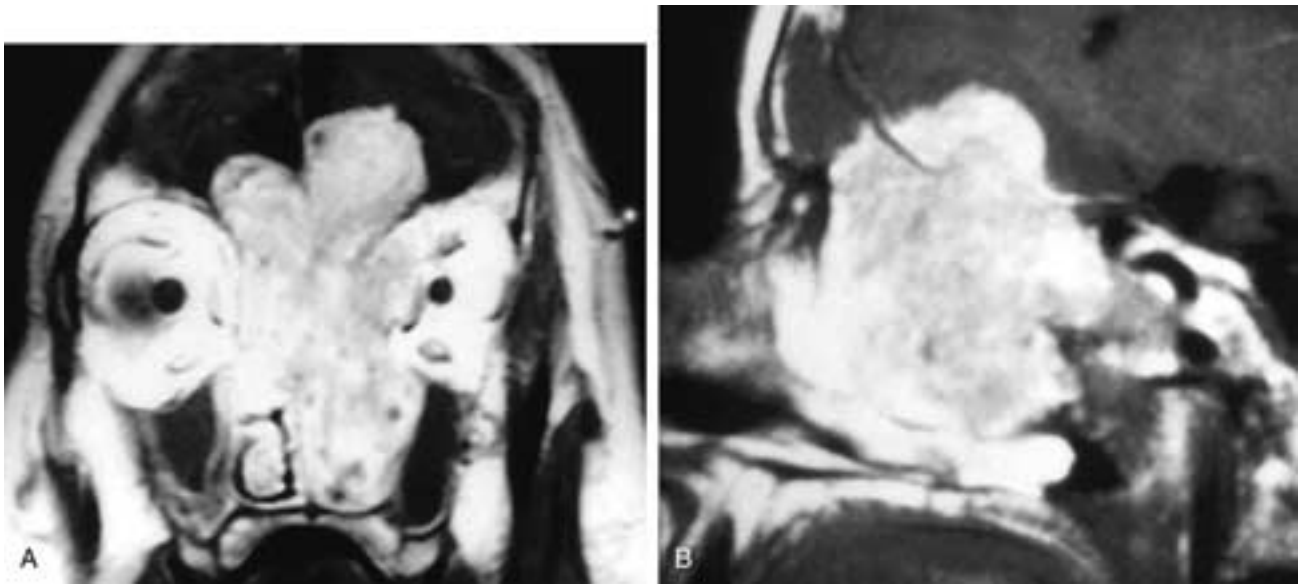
Coronal (A) and sagittal (B) T1-weighted, contrast-enhanced MR images show a large, enhancing nasal fossa mass that has broken through the floor of the anterior cranial fossa and displaced the frontal lobes upward. The tumor has also extended into each orbit and into the left maxillary sinus. This patient had an olfactory neuroblastoma.
